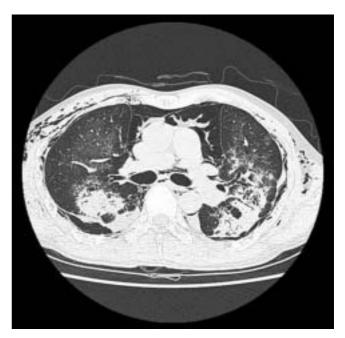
High-resolution computed tomography (HRCT) thorax of a patient with severe acute respiratory syndrome (SARS) complicated by spontaneous pneumomediastinum, subcutaneous emphysema and rims of bilateral pneumothoraces.
